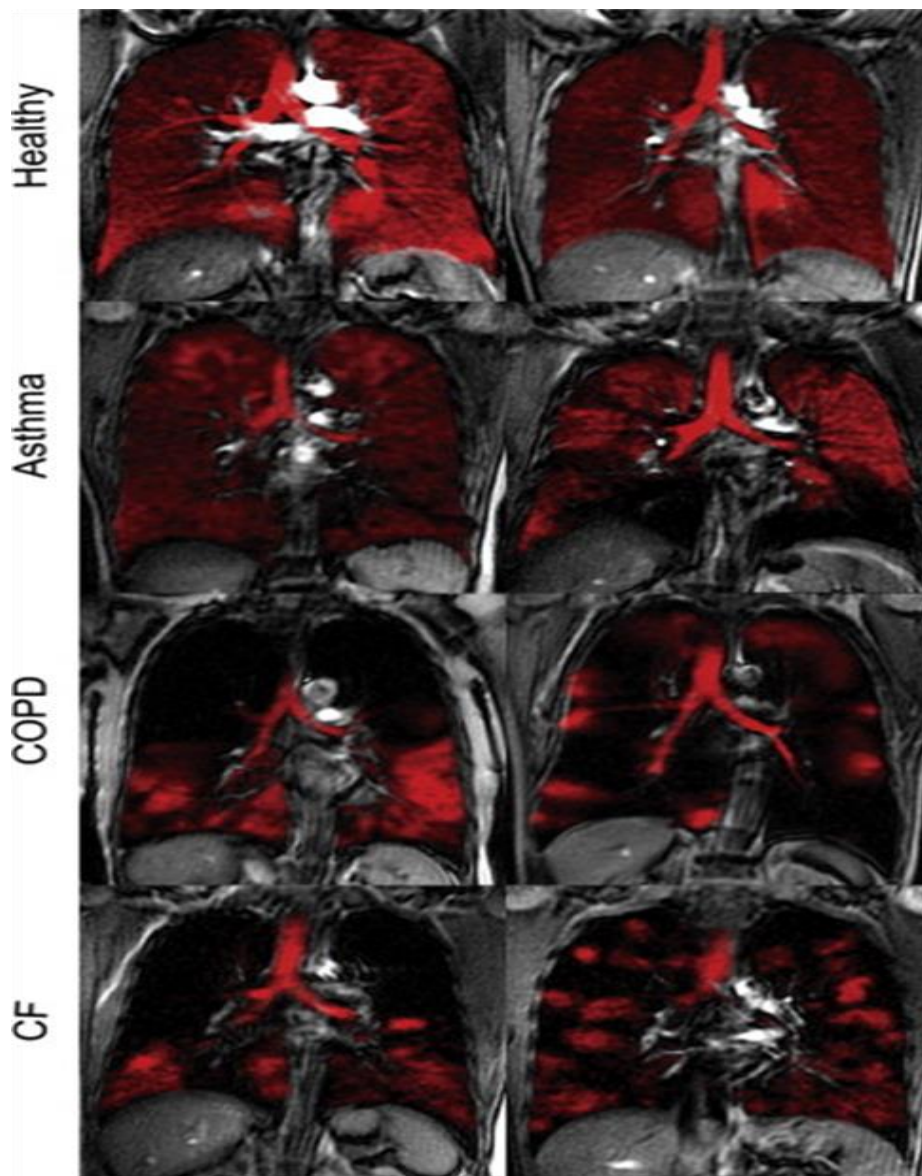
Hp ^{129}Xe slice selective coronal MR images (in red) overlaid onto corresponding proton thoracic images from healthy volunteers and subjects with asthma, chronic obstructive pulmonary disease (COPD), cystic fibrosis (CF) (Lilburn et al., 2013).
